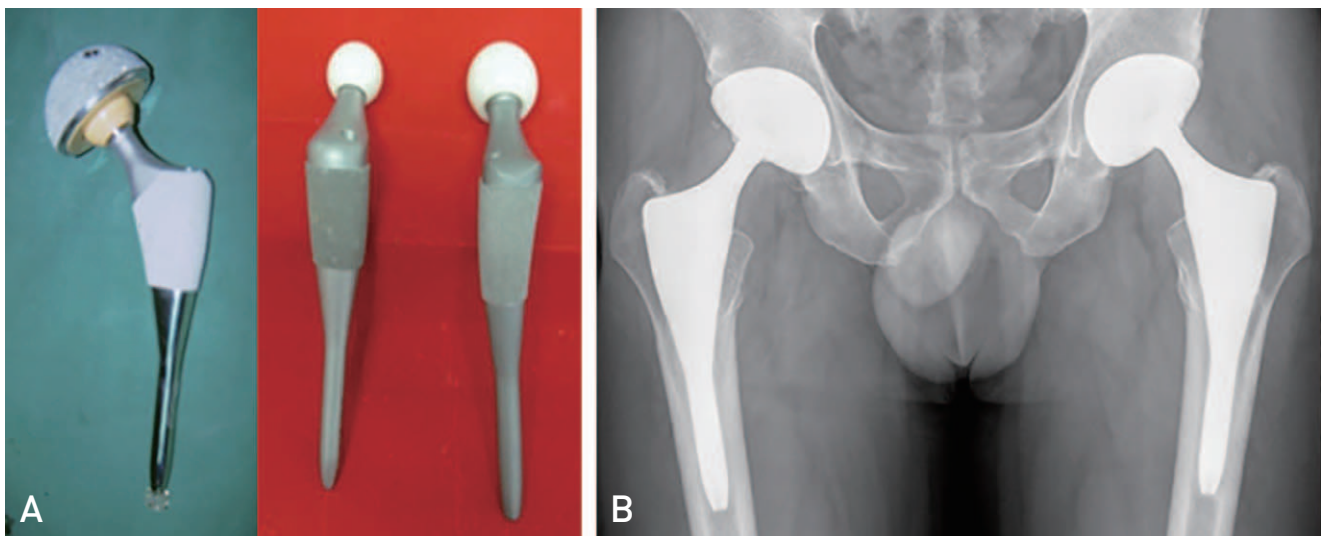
(A, B) Photos of an IPS (Immediate Postoperative Stability; DePuy) stem and radiographs of both hips taken 20 years after the operation.
